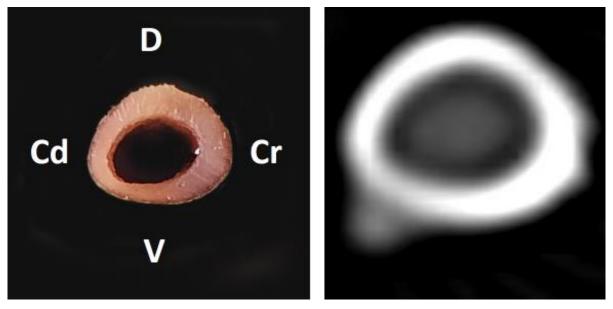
The cross-sectional view of right ulna (photograph and CT scan)
